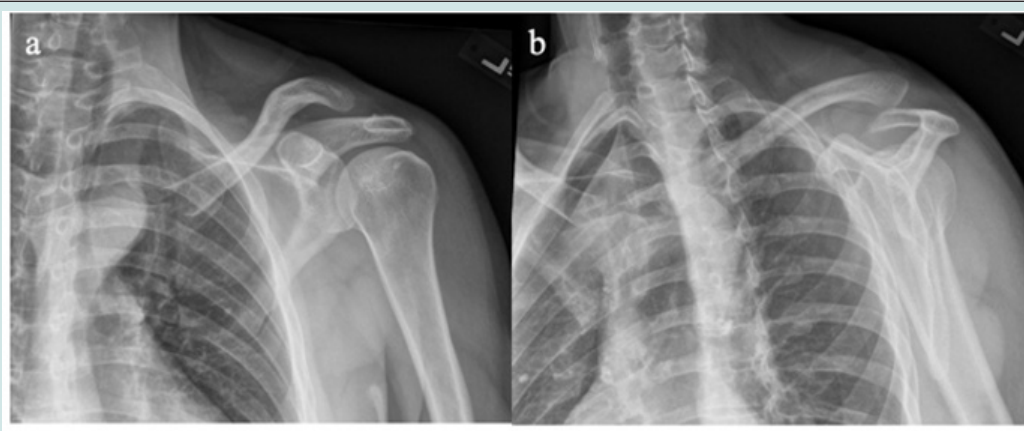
Grashey (a) and Scapular-Y(b) x-rays of left shoulder taken the day of the injury showing left AC joint separation.
